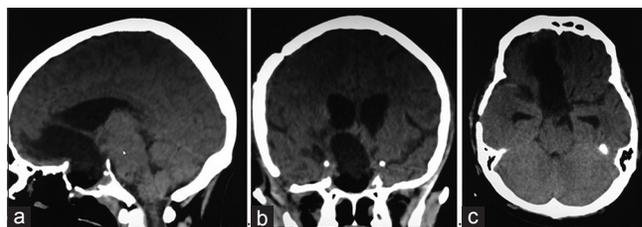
Gross total resection of the tumor was confirmed based on the sagittal (a), coronal (b), and axial results (c) from the postoperative computed tomography
